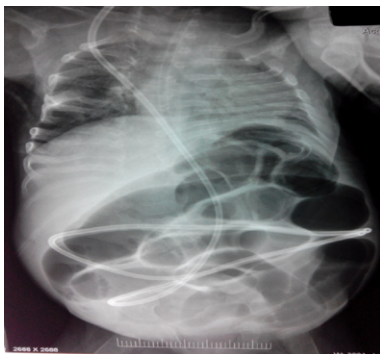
Dilated bowel loops with air fluid levels in the plain abdominal X-ray.
